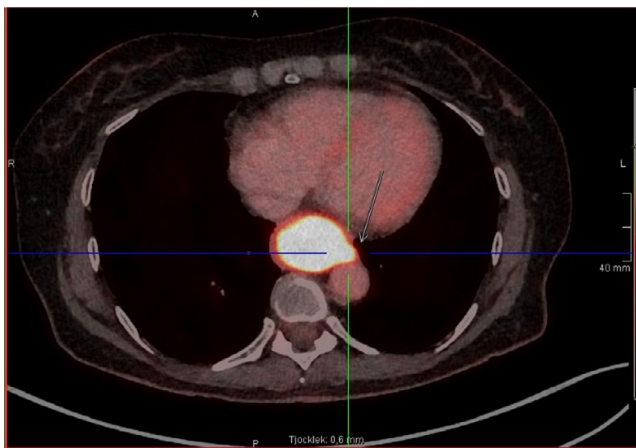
PET-CT with an increased uptake of fluorodeoxyglucose in the lower part of esophagus
